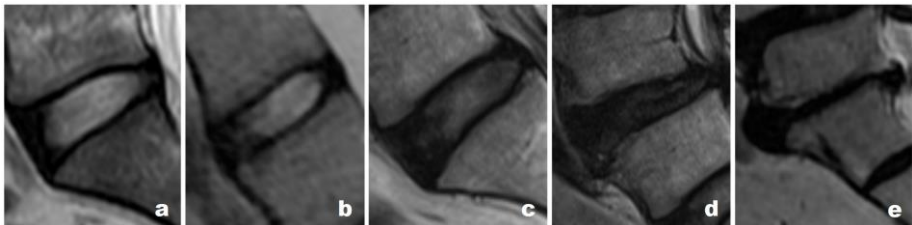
Sagittal view of L5-S1 intervertebral discs of different degeneration grades examined with T2-weighted MRI. According to the Pfirrmann classification, the intervertebral discs are graded as follows: (a) Grade I, (b) Grade II, (c) Grade III, (d) Grade IV, (e) Grade V.
